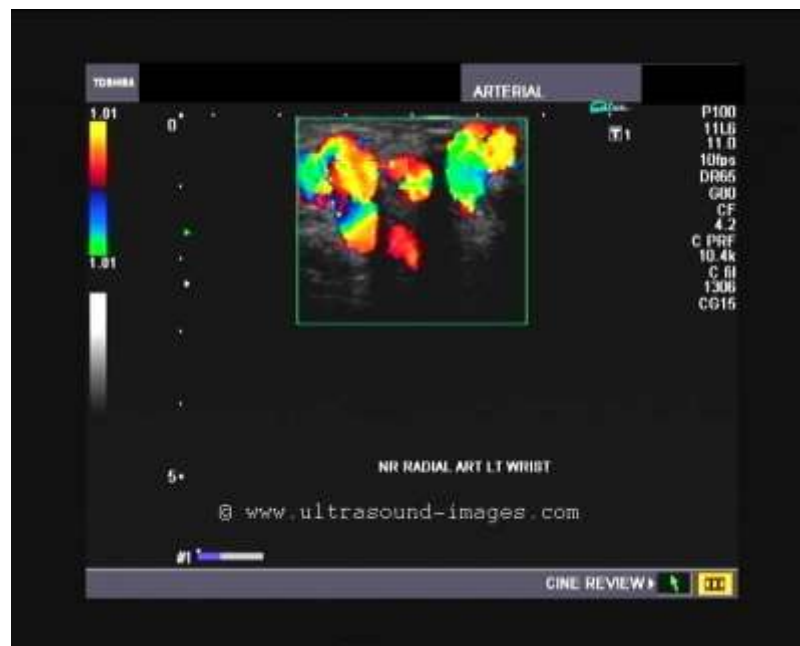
A sample Doppler mode ultrasound image
